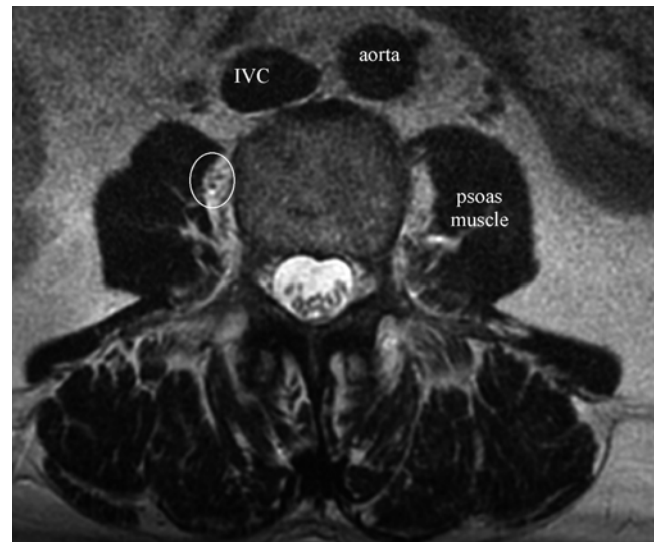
Axial MRI image of the lumbosacral plexus (Image courtesy of Andrea Trescot, MD)
